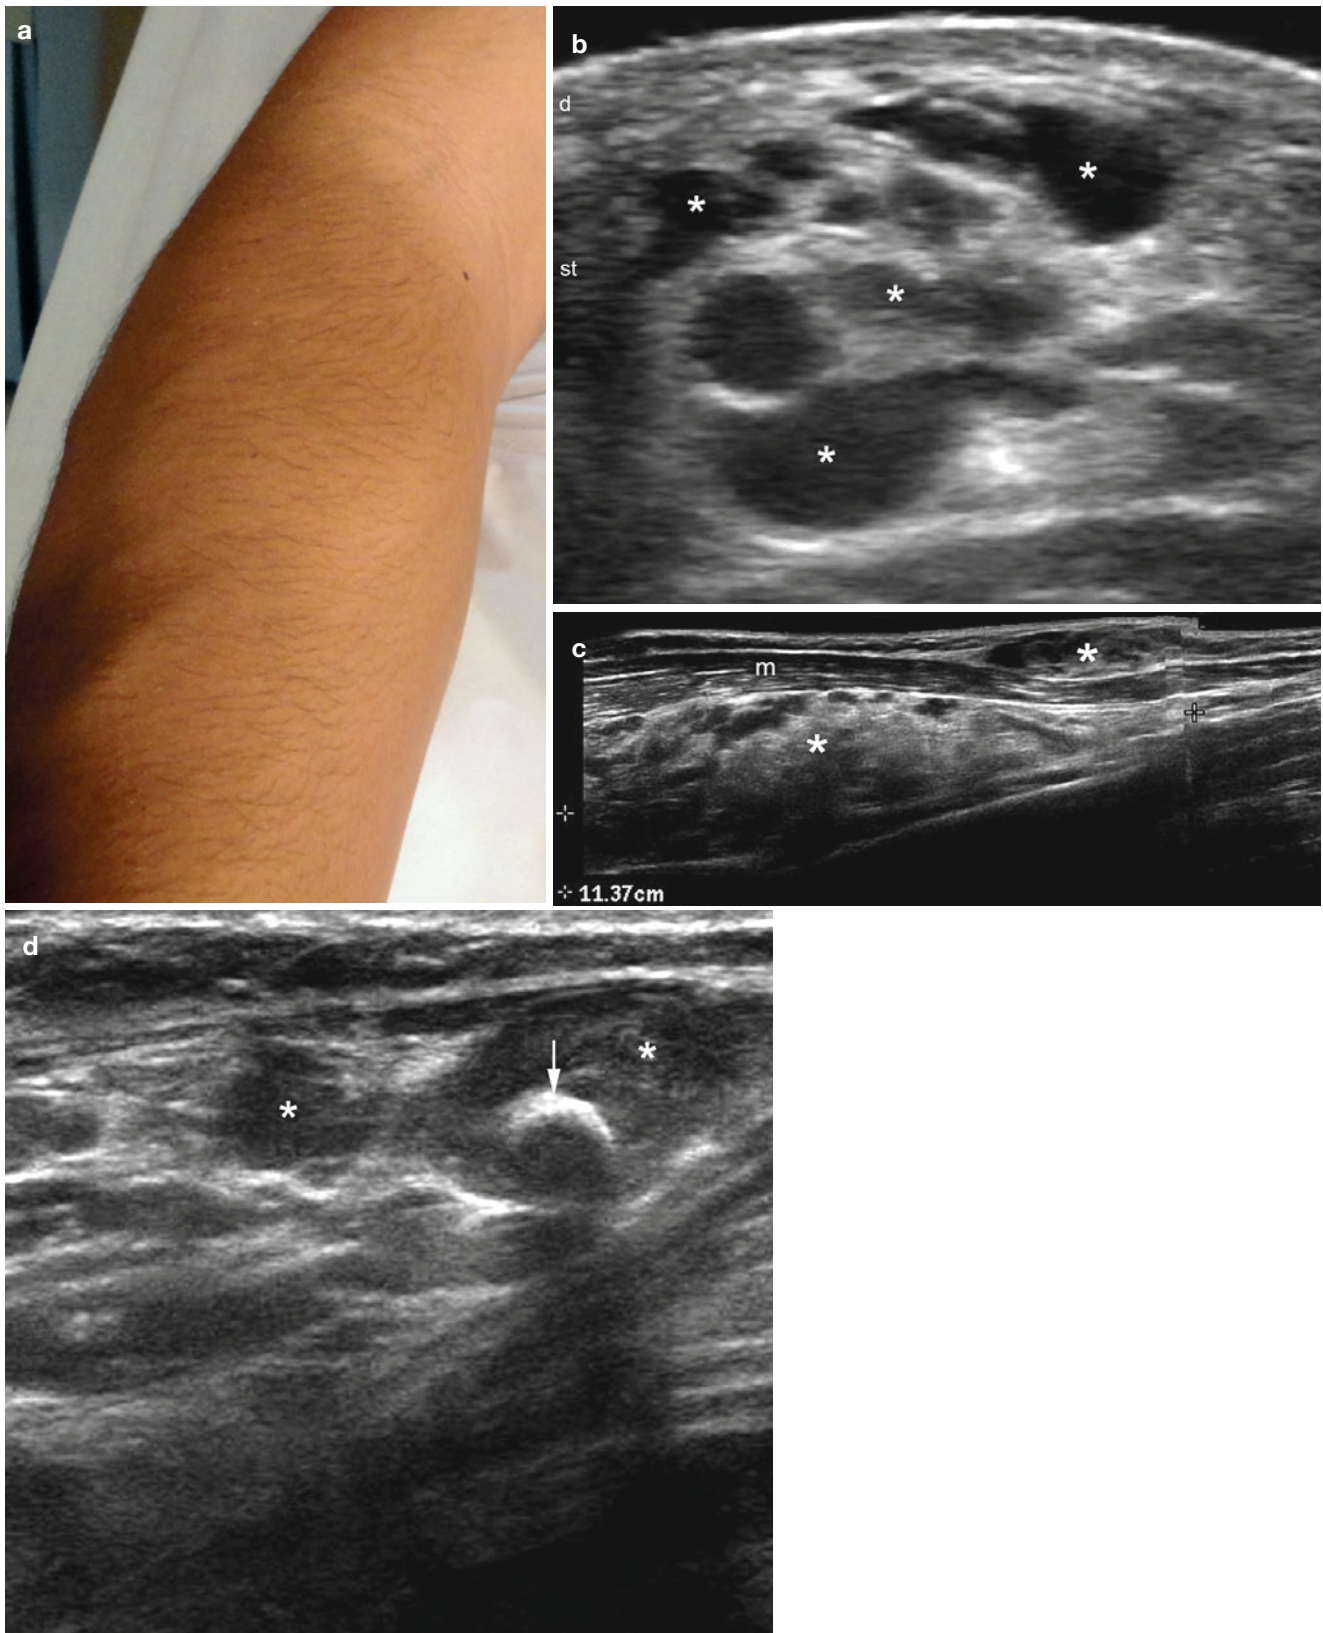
(a–e) Low-flow venous vascular malformation. (a) Clinical lesion shows a swelling in the right arm and forearm. (b) Grey scale ultrasound image (transverse view) shows multiple anechoic pseudocystic structures (*) in the subcutaneous tissue. (c) Grey scale ultrasound image (extended field longitudinal view) in the forearm
